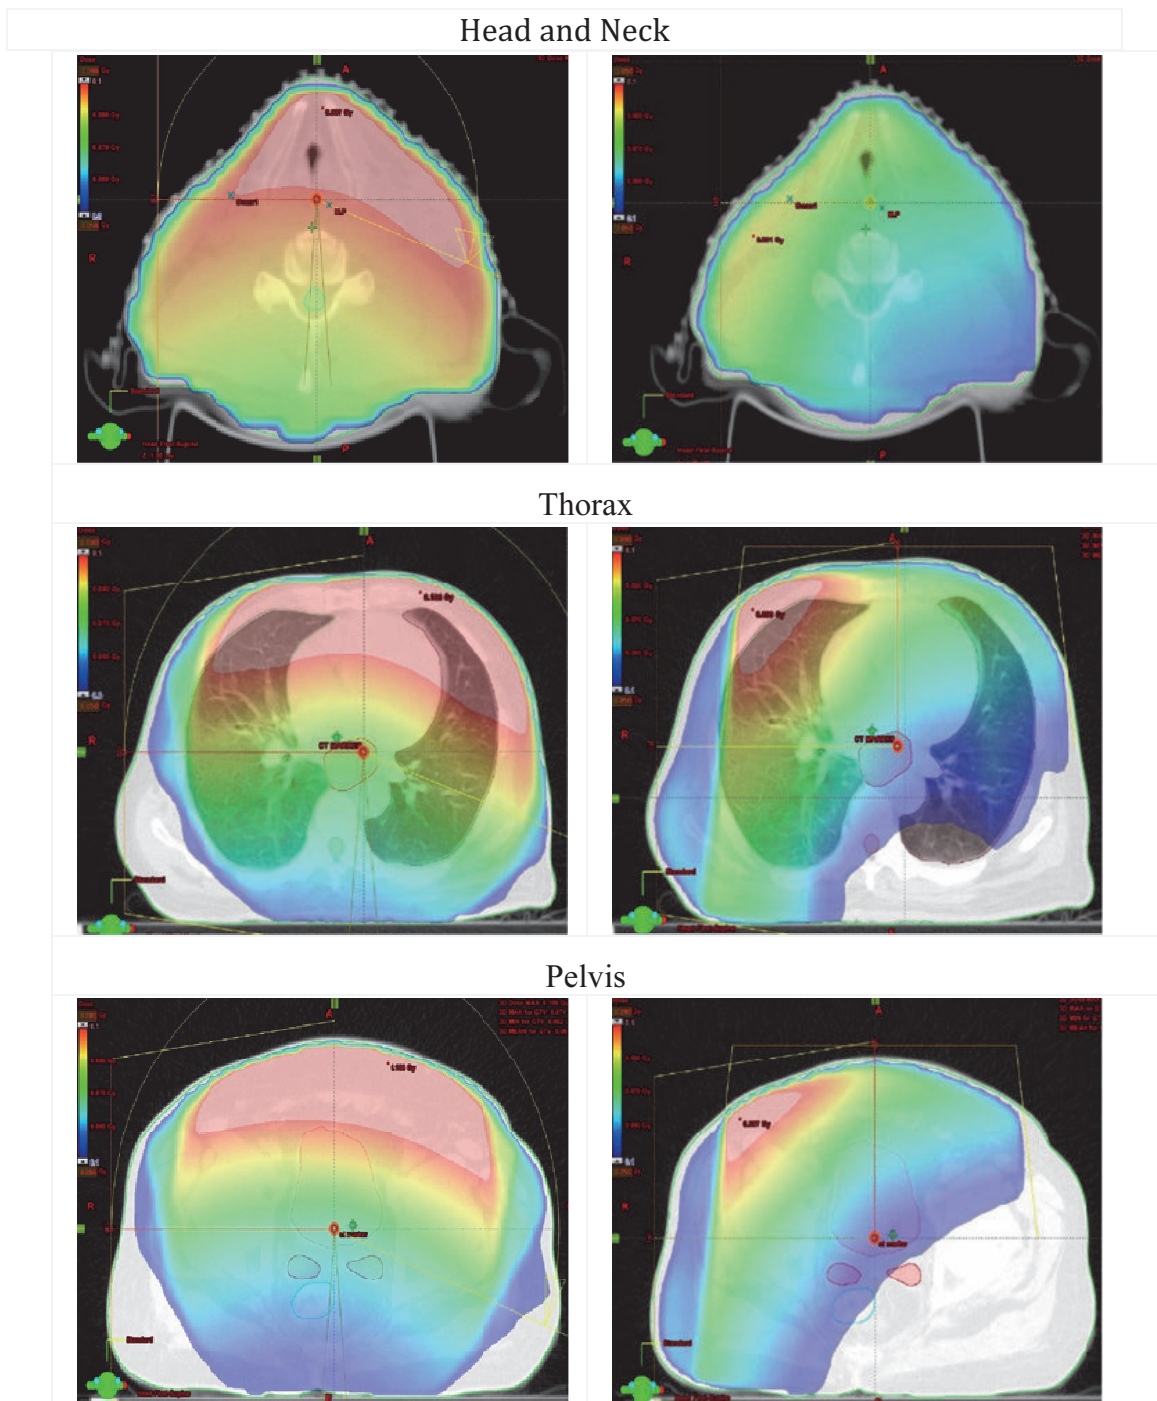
The 2D absolute dose distribution of transverse central slice evaluated in various treatment sites using MV CBCT imaging with 8 MU (left panels) and orthogonal portal imaging with 6 MU (right panels).
